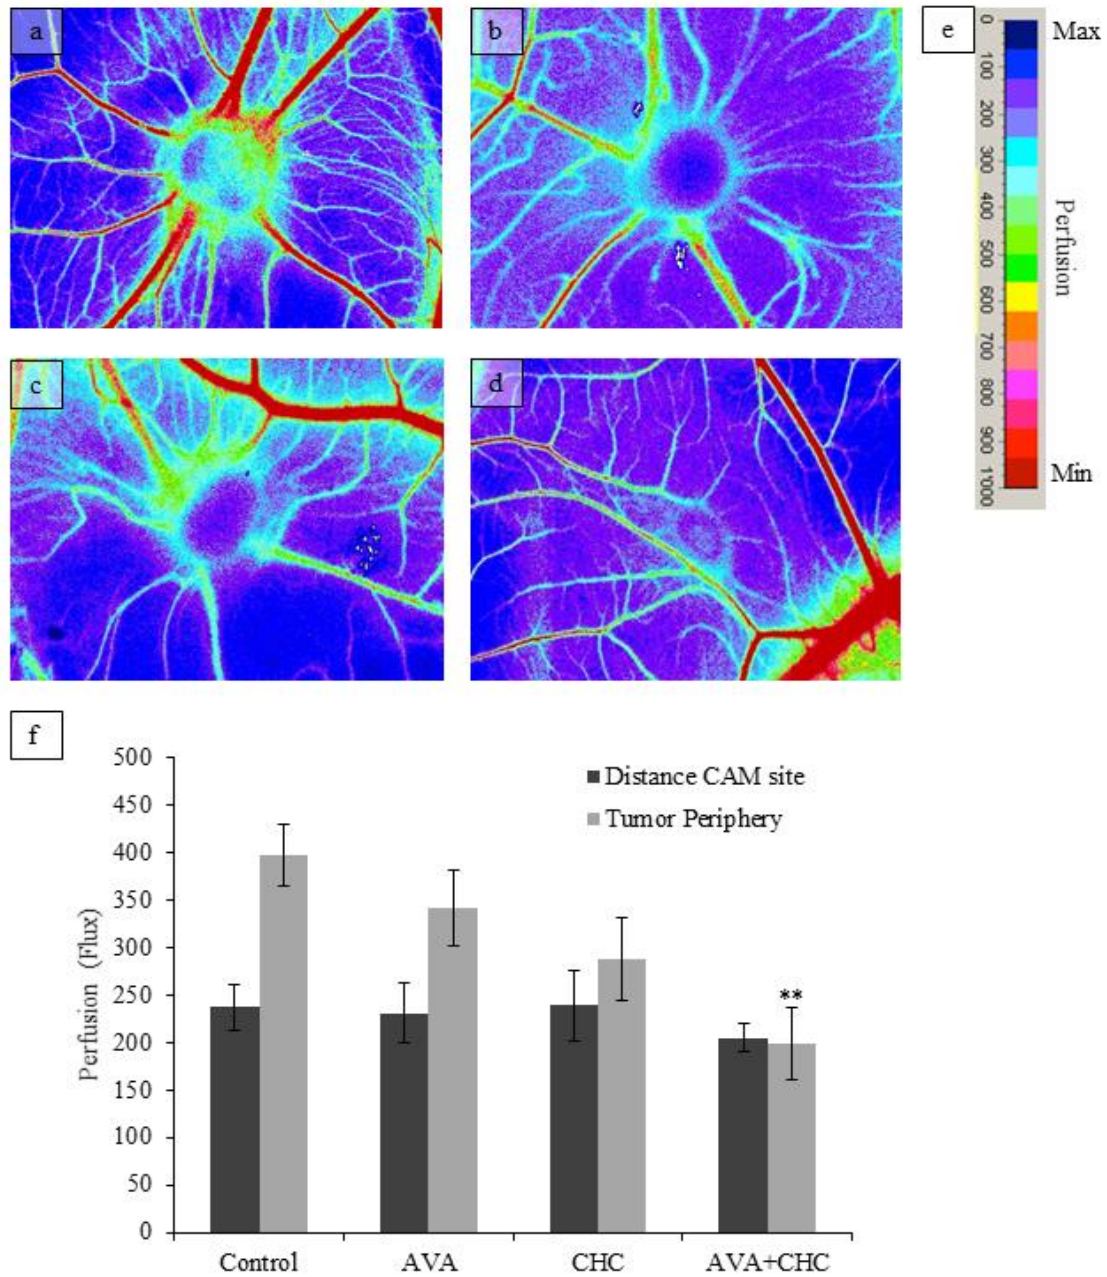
Laser Doppler blood perfusion imaging of U87 tumor explants. Panels a-e show representative blood flow recordings from tumors treated with (a-d) PBS (control), AVA, CHC and AVA+CHC (application mode and concentration used as in figure 13). e) Color scale for perfusion. f) Quantified blood flow (flux) measurements in U87 tumors in response to the indicated treatments. Note the significant reduction of peripheral tumor blood flow to almost CAM levels in response to AVA+CHC combinational treatment. Data are means
